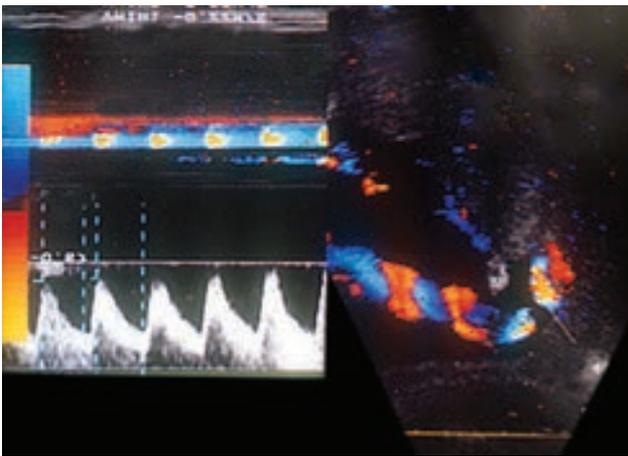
Pulsed Doppler umbilical arterial blood flow curve and color Doppler flow mapping of umbilical cord
